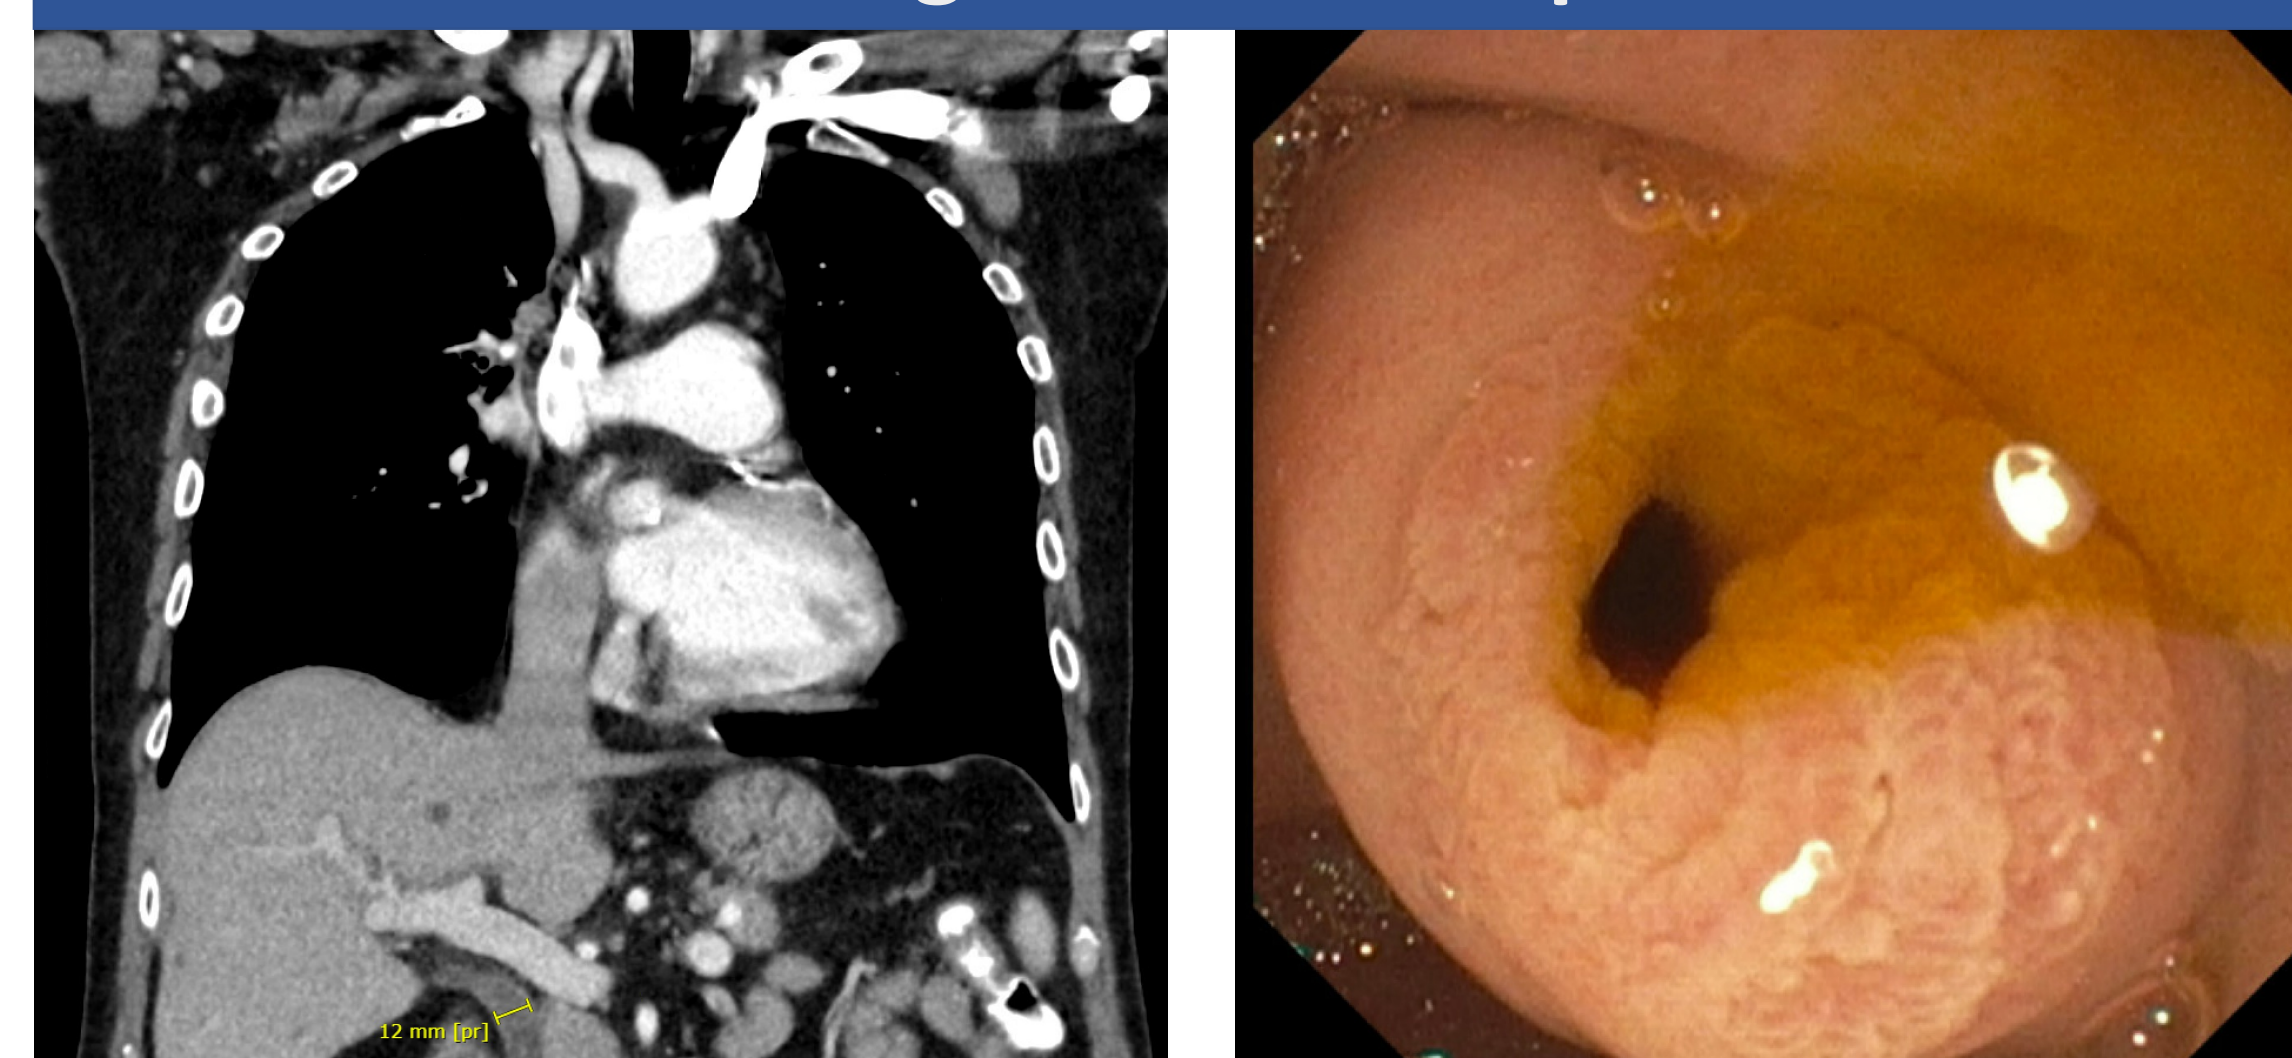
CT chest/abdomen with contrast (coronal view) showing common bile duct dilation of 1.2cm (yellow calipers) status post cholecystectomy
